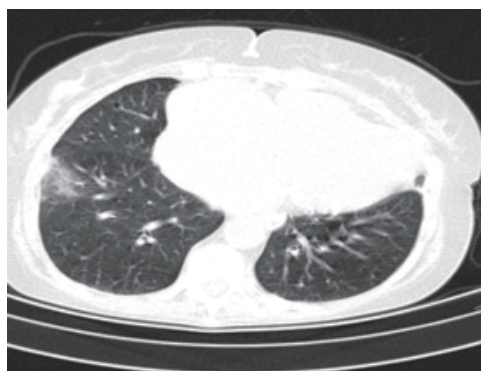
Frosted glass image of Case 2 in Thorax CT
